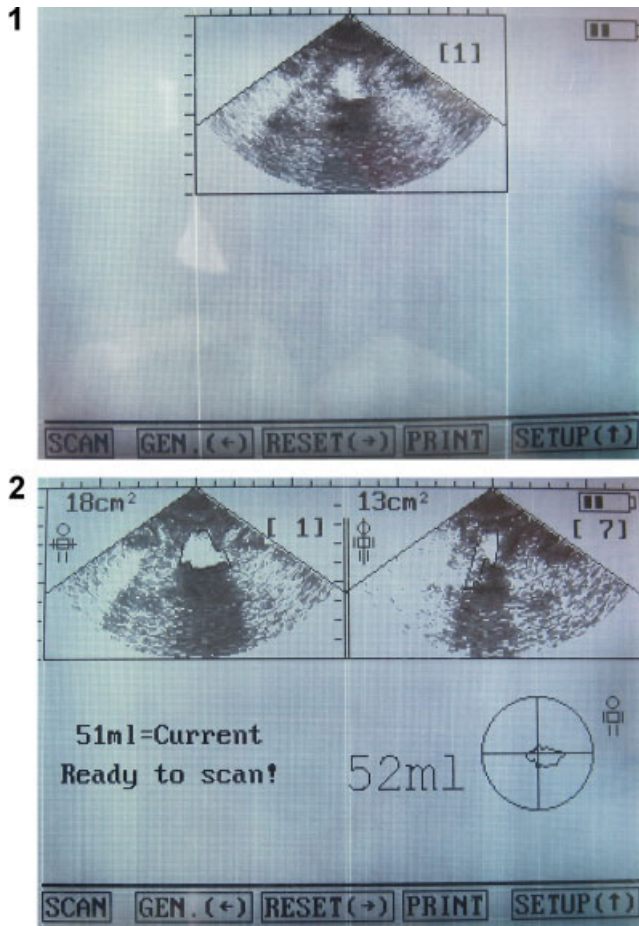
Portable ultrasound bladder scanner with real-time pre-scan imaging (transverse plane). (1) Scanning in progress. (2) Completion of scanning.
